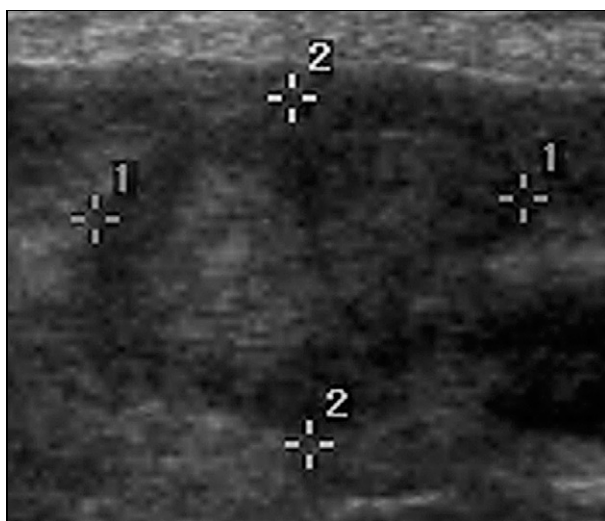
Ultrasonographic imaging of a thyroid nodule. Note the internal calcifications. The patient was diagnosed ultimately as having PTC and underwent a total thyroidectomy followed by radioactive iodine ablation.
